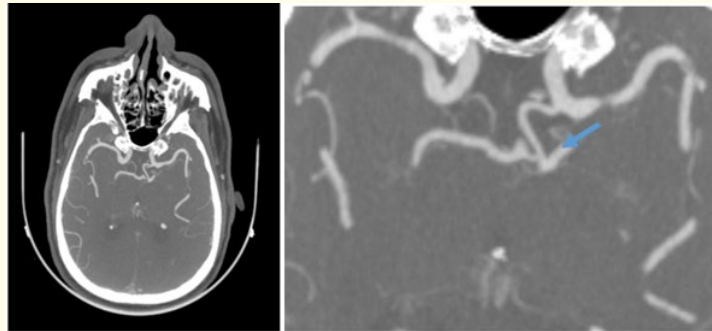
Brain CT scan in axial sections after contrast injection showing a tortuous appearance of the left posterior communicating artery (arrow).
